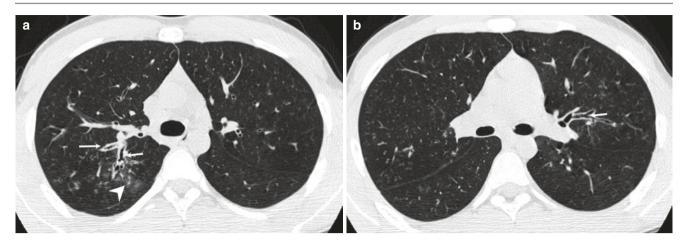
An 18-year-old boy with steroid-resistant asthma and ABPA. (a, b) Axial CT images show bronchiectasis (white arrows) with marked bronchial wall thickening. There are "tree-in-bud" opacities and diffuse
